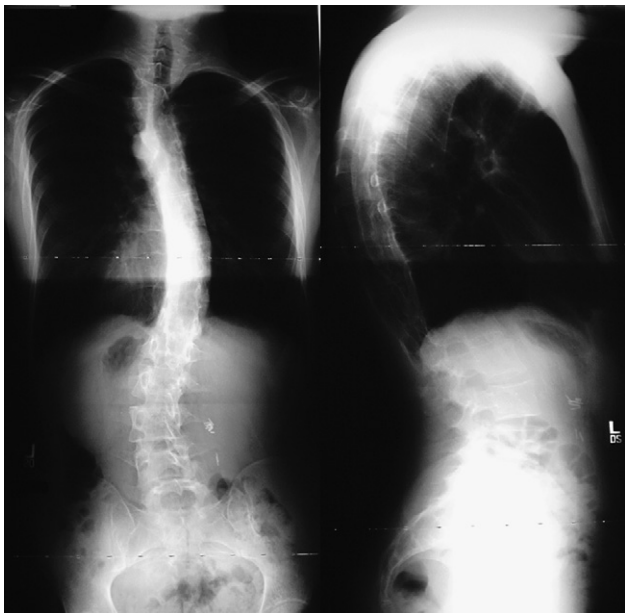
Posterior-anterior and lateral standing radiographs, 9 years after posterior spinal fusion and 6 years after removal of instrumentation. No significant radiographic findings present.
